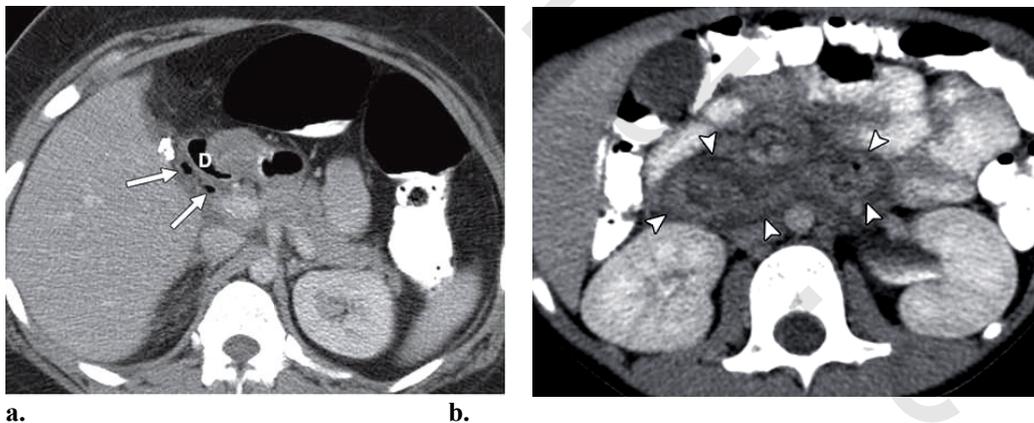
Abdominal CT scan obtained with IV and oral contrast.
